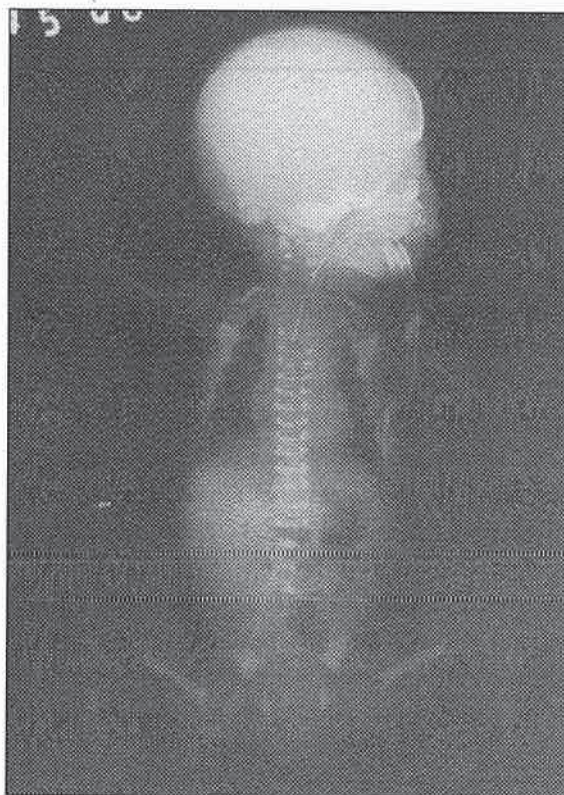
Radiograph of the patient. Note the moth-eaten appearance of the major long bones resulting from unmineralised osteoid protruding into the metaphysis.
